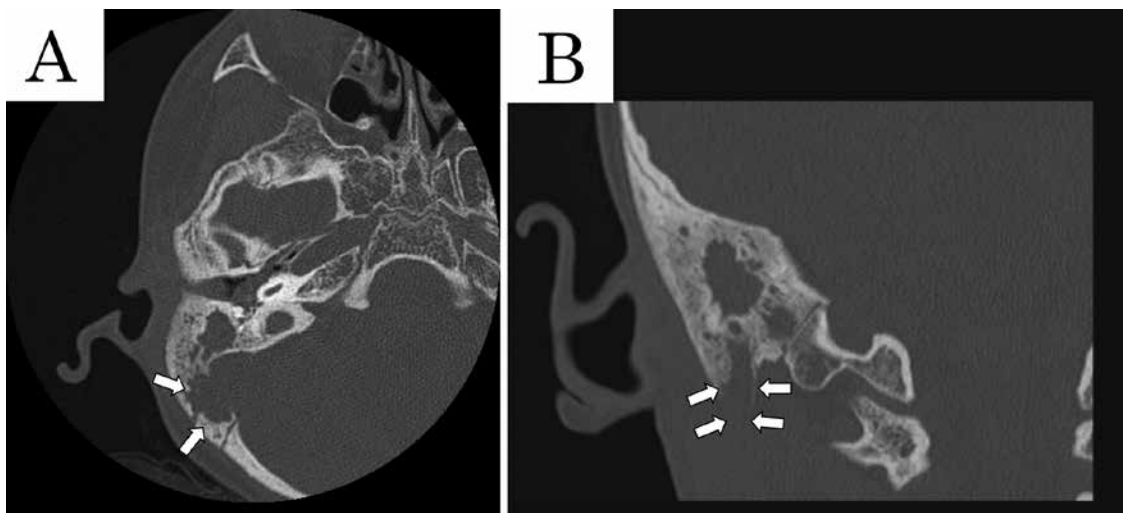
Computed tomography (CT) scan at the time of hospital arrival. The mastoid cavity was filled with soft tissue, with bony destruction of the sigmoid sinus and posterior cranial fossa (A) and a bony defect at the mastoid process tip (B).
